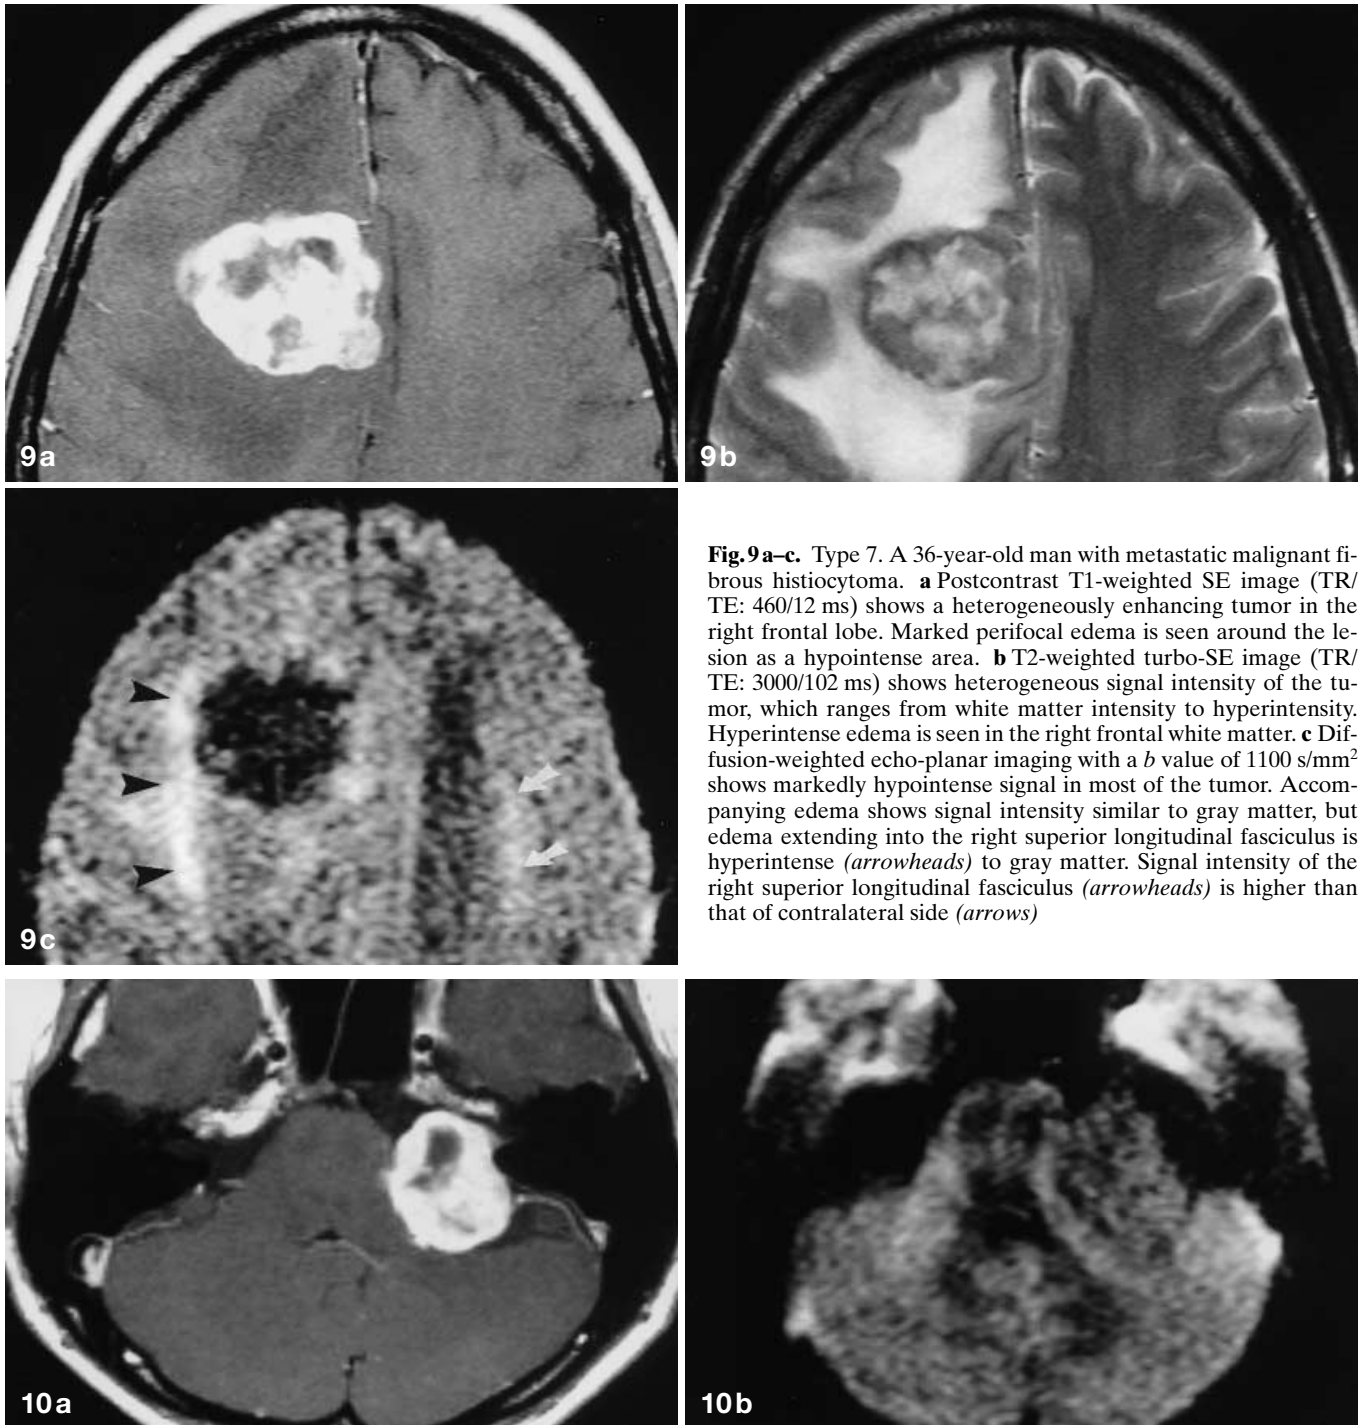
a–c. Type 7. A 36-year-old man with metastatic malignant fibrous histiocytoma. a Postcontrast T1-weighted SE image (TR/TE: 460/12 ms) shows a heterogeneously enhancing tumor in the right frontal lobe. Marked perifocal edema is seen around the lesion as a hypointense area. b T2-weighted turbo-SE image (TR/TE: 3000/102 ms) shows heterogeneous signal intensity of the tumor, which ranges from white matter intensity to hyperintensity. Hyperintense edema is seen in the right frontal white matter. c Diffusion-weighted echo-planar imaging with a b value of 1100 s/mm^2 shows markedly hypointense signal in most of the tumor. Accompanying edema shows signal intensity similar to gray matter, but edema extending into the right superior longitudinal fasciculus is hyperintense (arrowheads) to gray matter. Signal intensity of the right superior longitudinal fasciculus (arrowheads) is higher than that of contralateral side (arrows)
